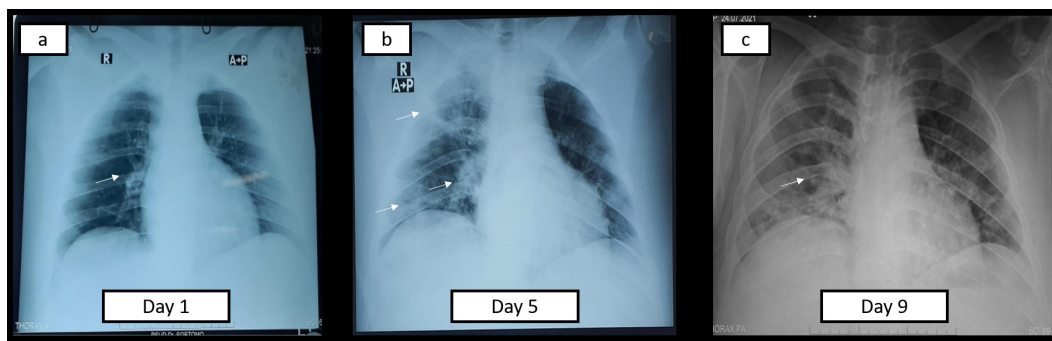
Chest radiographic progression. Initial chest X-ray (a) showed a right pericardiac possible pulmonary infiltrate. On the 5th day (b), air space consolidation opacities are at the periphery of the right lung and the midzones. On the 9th day follow-up chest X-ray (c), the consolidation was partially resolved along with clinical improvement.
